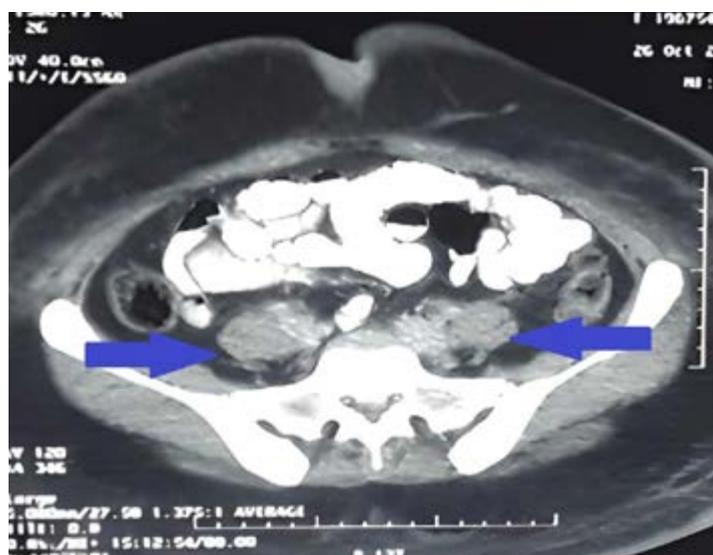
Axial abdominal CT scan identifying multiple clusters of retroperitoneal para-aortic adenopathy (arrows)
